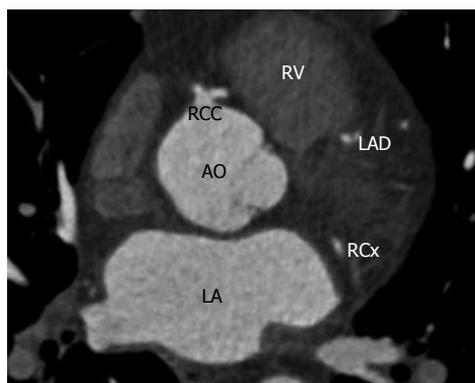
Multi-slice computed tomography showed the anomalous left main coronary artery originating from the ostium of the right coronary artery. AO: Aorta; LA: Left atrium; RV: Right ventricle; RCC: Right coronary cusp; LAD: Left anterior descending; RCx: Ramus circumflex.
